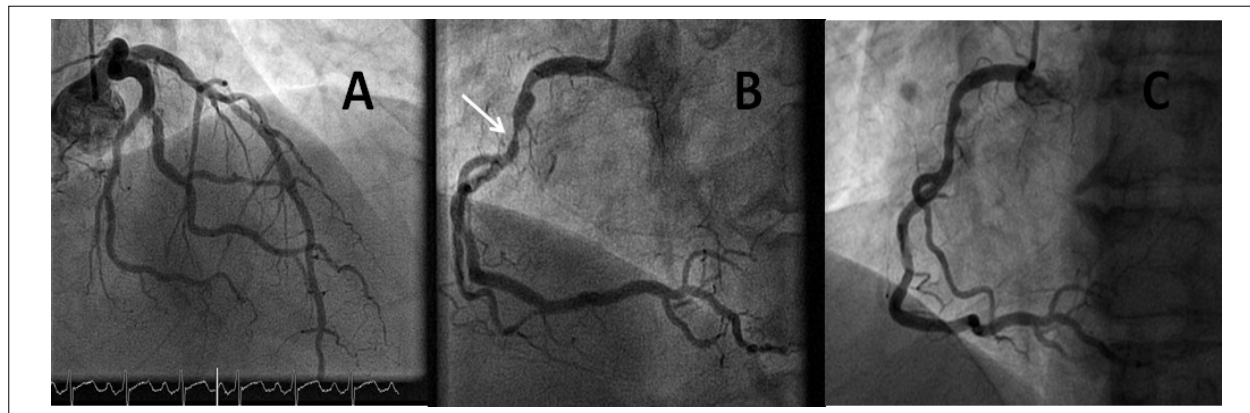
ICA after stress echocardiogram. A) ICA in caudal right oblique projection that demonstrates mild plaque in proximal LAD. B) ICA in left anterior oblique projection that showed severe obstruction in RCA (arrow). C) ICA in left anterior oblique projection after the implant of bioabsorbable scaffold in RCA. ICA: invasive coronary angiography LAD: left anterior descending artery. RCA: right coronary artery.
